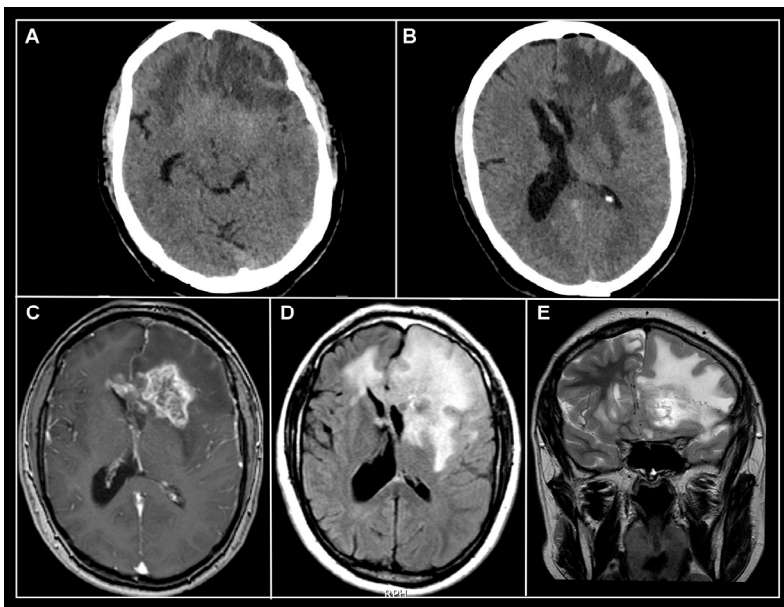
Male patient with GBM in the left frontal lobe, shown by computed tomography (A–B) and magnetic resonance imaging with gadolinium contrast enhancement (C–E). Images were kindly provided by Dr Julio Enríquez Viteri.
